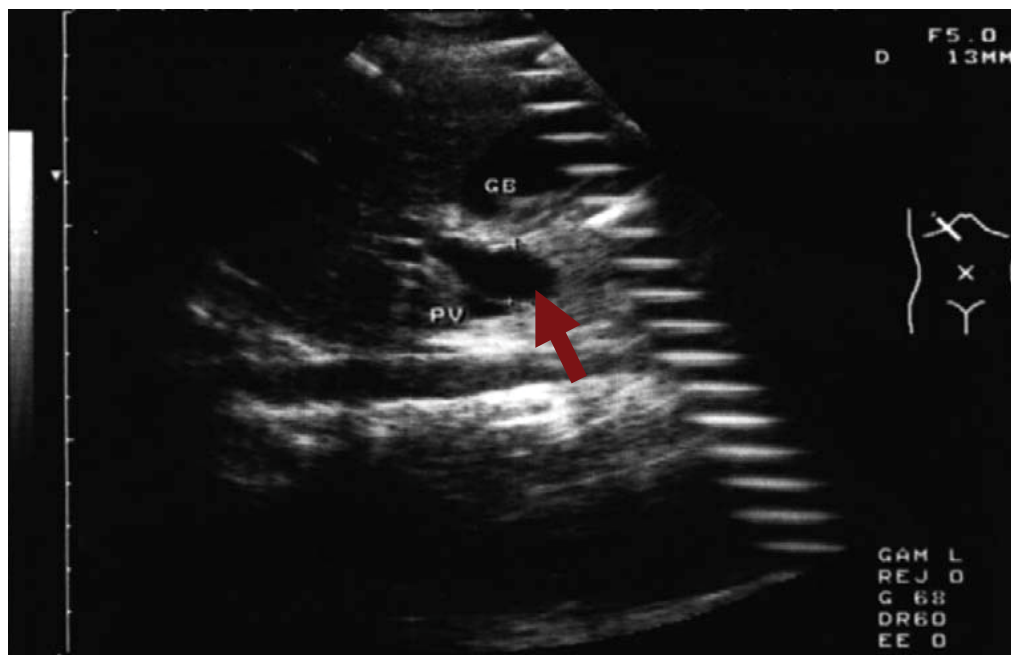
Choledochal cyst Type Ic: a fusiform dilatation (arrow) in the common bile duct. PV = portal vein; GB = gallbladder. (From Lee HC: *J Med Ultrasound* 2007;15(3):191-196.)
